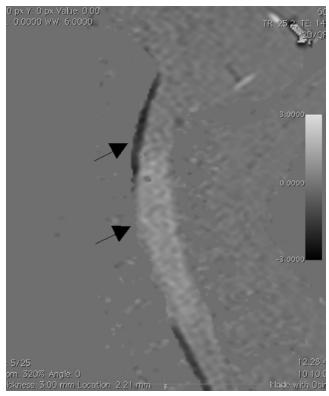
Cardiac-gated phase-contrast MR image showing phase shift between pulsations in the subarachnoid space and the syrinx cavity in a patient with CM-I. The *upper arrow* points to ventral pulsations in the subarachnoid space of the upper cervical cord. The image shows complete compression of the subarachnoid space by the syrinx and ventral pulsations in the caudal direction. The *lower arrow* points to the area where the syrinx is largest in diameter. No pulsation can be detected in the subarachnoid space. Pulsations can only be observed in the syrinx cavity, where CSF flows in the cranial direction *(white)*. The image thus reveals pulsations in opposite directions.
